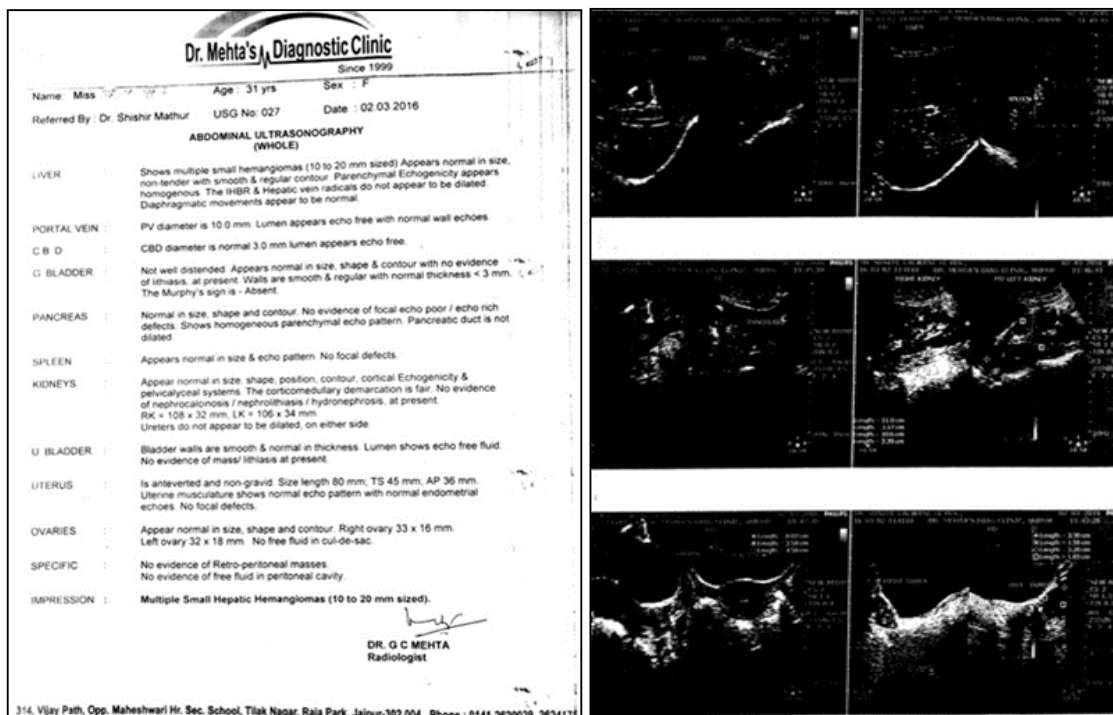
Post - treatment ultrasonography report
